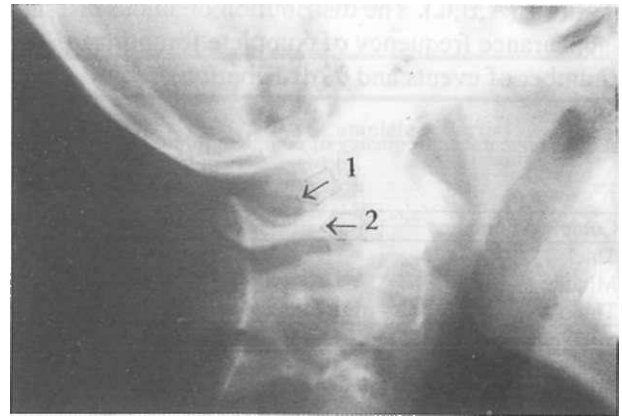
Anterior type of partial foramen at lateral cervical x-ray (from right side) 1: partial foramen, 2: arcus posterior of atlas.
